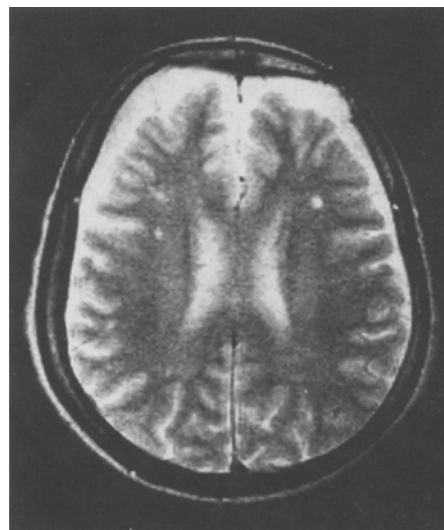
MRI of case 1. Note three small discrete lesions in the white matter (TR = 2000 ms, TE = 80 ms)
